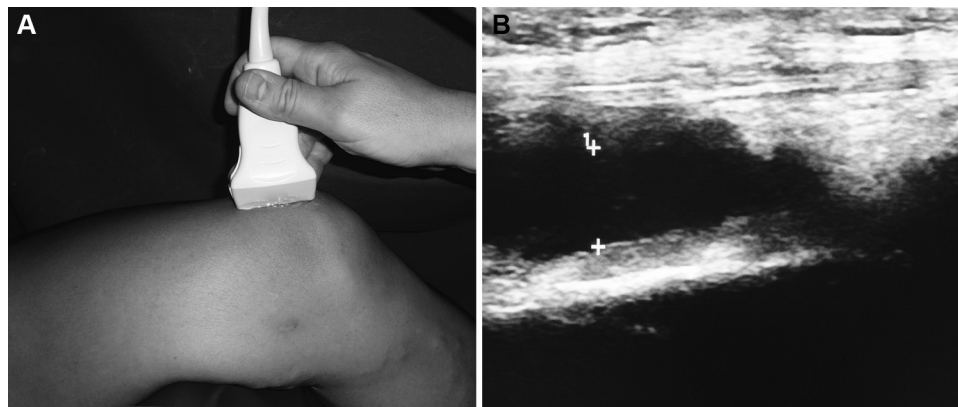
Knee effusion and probe position. (A) Probe position in the suprapatellar compartment. The probe is directly above the patella in the middle line. (B) Ultrasound of knee effusion (measured length: 2.5 cm) in a soccer player with osteoarthritis. Any effusion larger than 4 mm was considered evidence of osteoarthritis.
